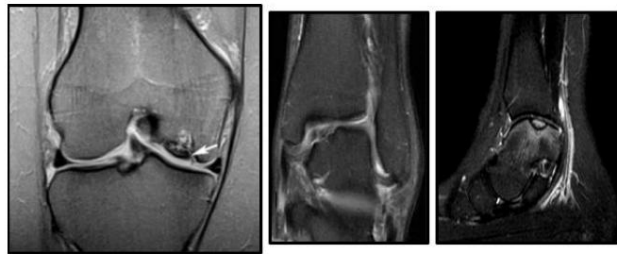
MRI of the unstable lesion in the coronal view of the knee (left) and in the coronal and sagittal view of the ankle (center/right). Images taken from the work of Grimm N., et al. (9) and Bauer KL, & Polousky, JD (12)
